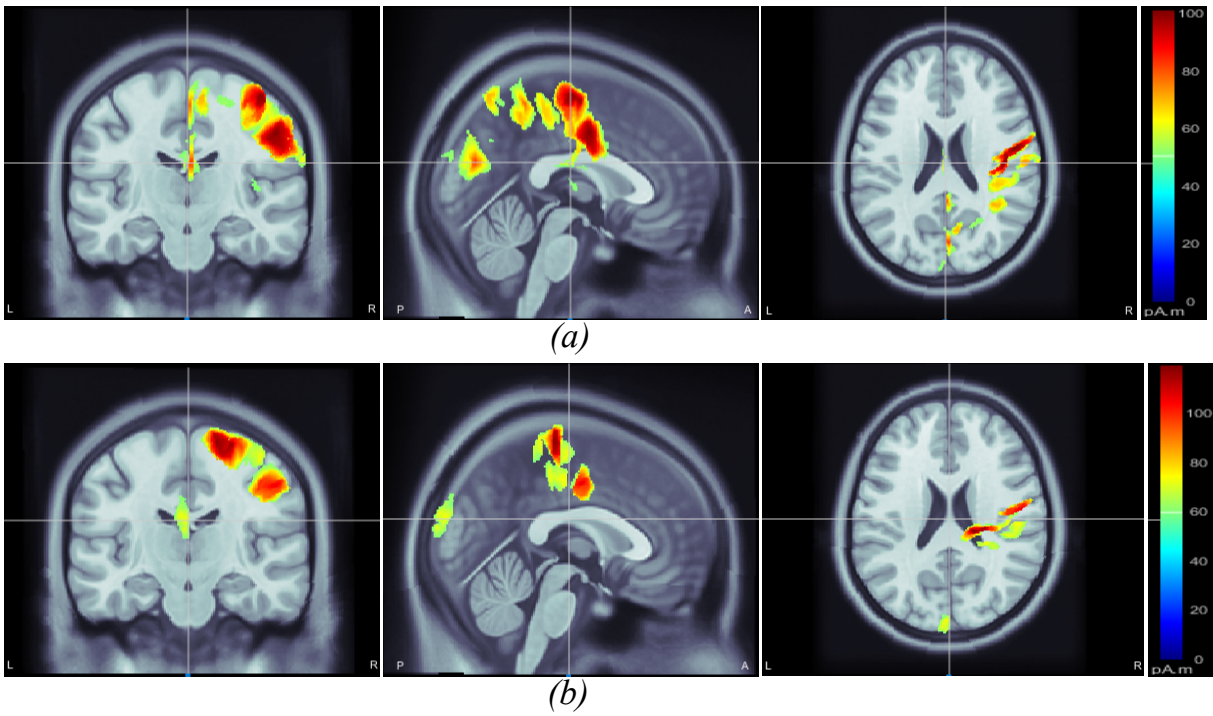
Motor imagery induced inter-subject (subject pair *al-ay*) cortical sources on a MRI head model estimated via wMEM: from left-right, coronal view, sagittal view and axial view, respectively for two motor imagery tasks: (a) right hand and (b) right foot movement.
